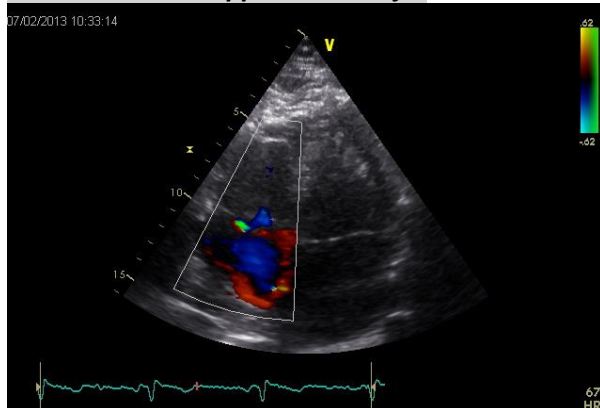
Color Doppler TV
